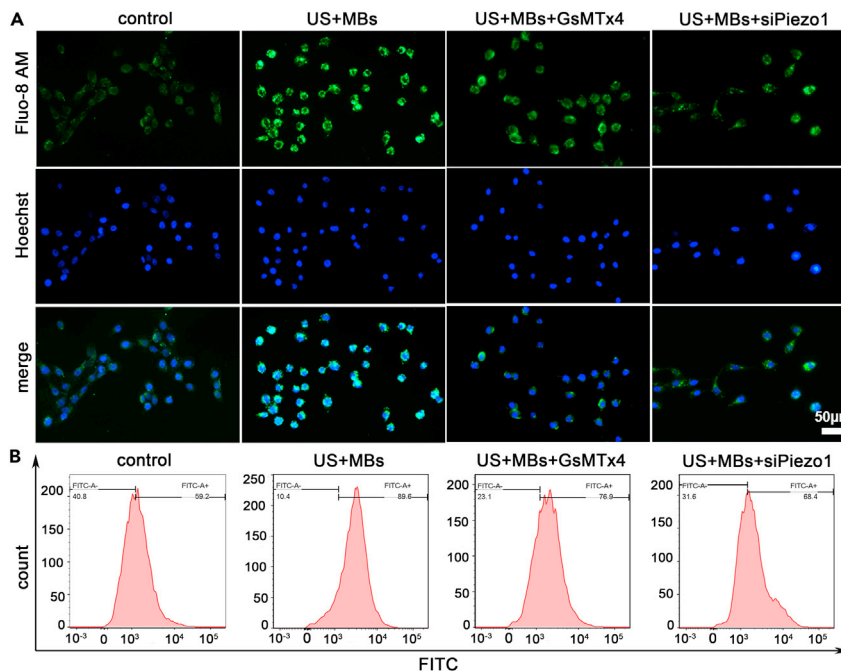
Piezo1 partially mediates influx of Ca^{2+} induced by ultrasound with microbubbles in pancreatic cancer cells
